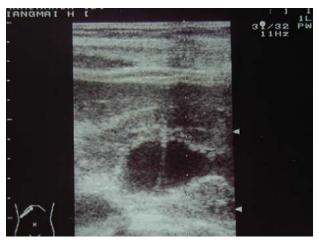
Ultrasound imaging demonstrated a guidewire in dilated pelvis.
